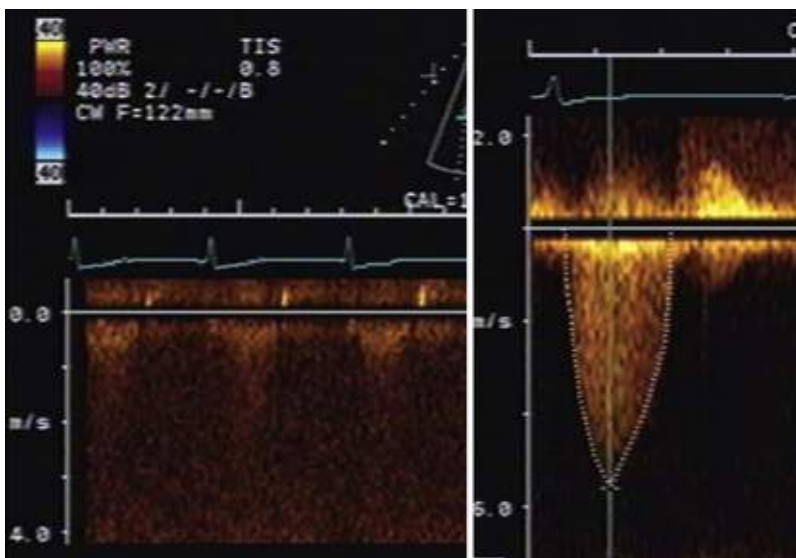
Use of echocardiographic contrast to enhance CW envelopes. Baseline unenhanced Doppler spectra (left panel) in this patient with valvular aortic stenosis are indistinct. Following administration of contrast material (right panel), the CW spectra are clearly defined.
